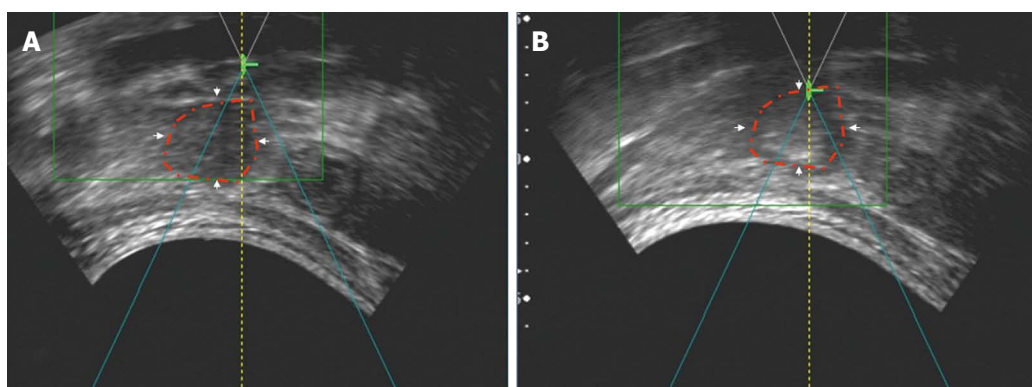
Grey-scale changes in a treated pancreatic cancer on real-time ultrasound images during high intensity focused ultrasound exposure. A: Ultrasound (US) image obtained before high intensity focused ultrasound (HIFU) shows a pancreatic cancer lesion present in the body of the pancreas (arrowheads); B: US image obtained immediately after the one-slice HIFU treatment shows the obvious hyperechogenicity of the treated pancreatic tumor (arrowheads).
